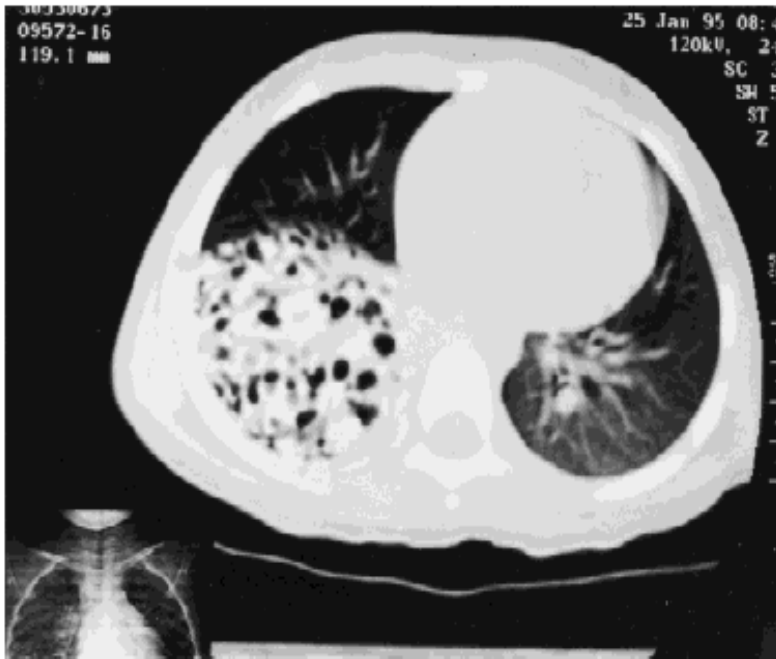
Computed tomography of chest demonstrating saccular bronchiectasis in right lower lobe.
